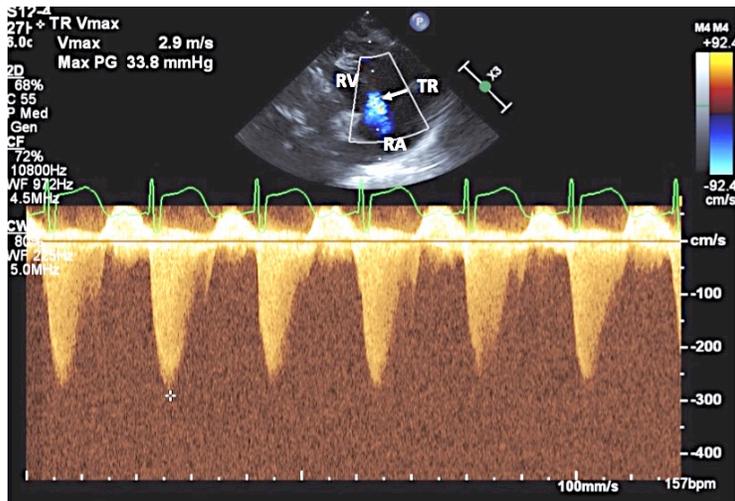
Two-dimensional and color Doppler recording to demonstrate tricuspid regurgitant (TR) jet (top) along with continuous wave Doppler recording of TR jet (bottom) is shown. This is used to calculate the pulmonary artery systolic pressure: peak velocity of 2.9 indicates 34 mmHg gradient (by modified Bernoulli equation) across the tricuspid valve. To this an assumed right atrial (RA) pressure of 5 mmHg is added to calculate the pulmonary artery pressure, assuming that there is no pulmonary outflow tract obstruction (see the text for details). RV, right ventricle.
